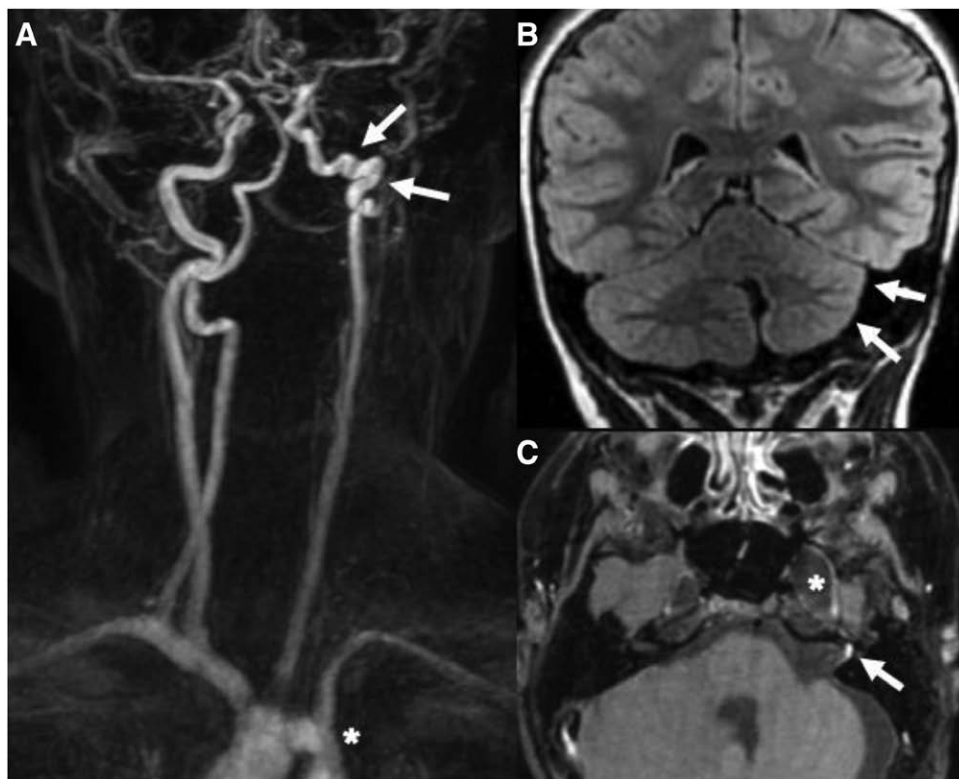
Representative images from a patient with PHACE. (A) MRA of the head and neck, with severe dysplasia of the left internal carotid artery (arrows) and aortic coarctation (*). (B) Coronal T2 FLAIR image showing unilateral left cerebellar hemisphere dysgenesis (arrows). (C) Enlarged left internal auditory canal containing a hemangioma and dural ectasia of the trigeminal cistern (*). MRA, magnetic resonance angiogram; PHACE, posterior fossa brain malformations, hemangioma, arterial lesions, cardiac abnormalities and aorta coarctation, and eye abnormalities.
